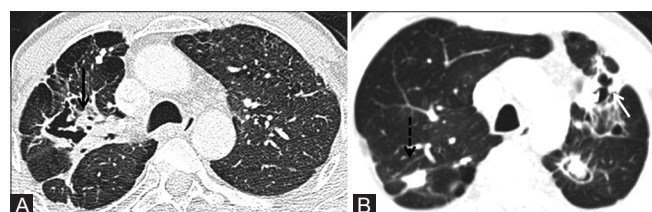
(A and B): Tuberculosis (TB): Fibrotic changes: (A) Axial high resolution computed tomography (HRCT) image (lung window) in a patient with healed TB shows unilateral fibroparenchymal changes with cavitation in right upper lobe (black arrow). (B) Axial CT image (lung window) in another patient shows asymmetric bilateral upper lobe involvement with parenchymal calcification (dashed arrow) and cavitation (white arrow) in another patient
